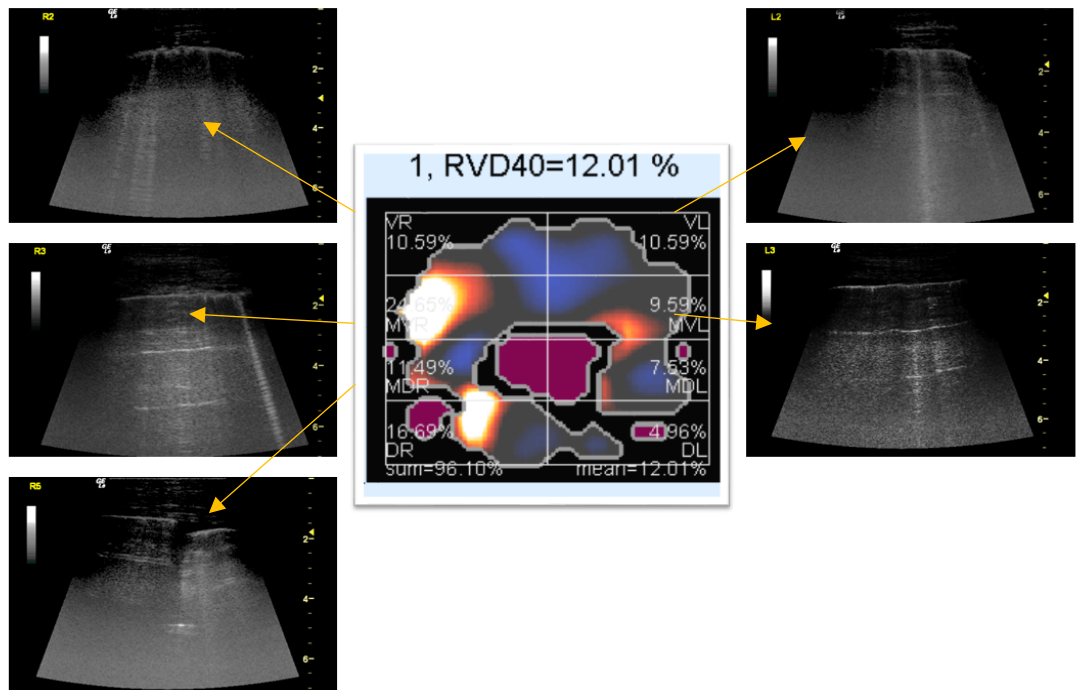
Example of electrical impedance tomography (EIT) image reconstruction and lung ultrasound (LUS) images. The EIT image represents the distribution of impedance to the eight regions of one representative patient. The lighter the color (yellow), the higher the regional ventilation delay (RVD). LUS images corresponding to the regions in the EIT image were shown additionally. Evaluation of LUS has been made using the whole clip because the single frame cannot show properly.
